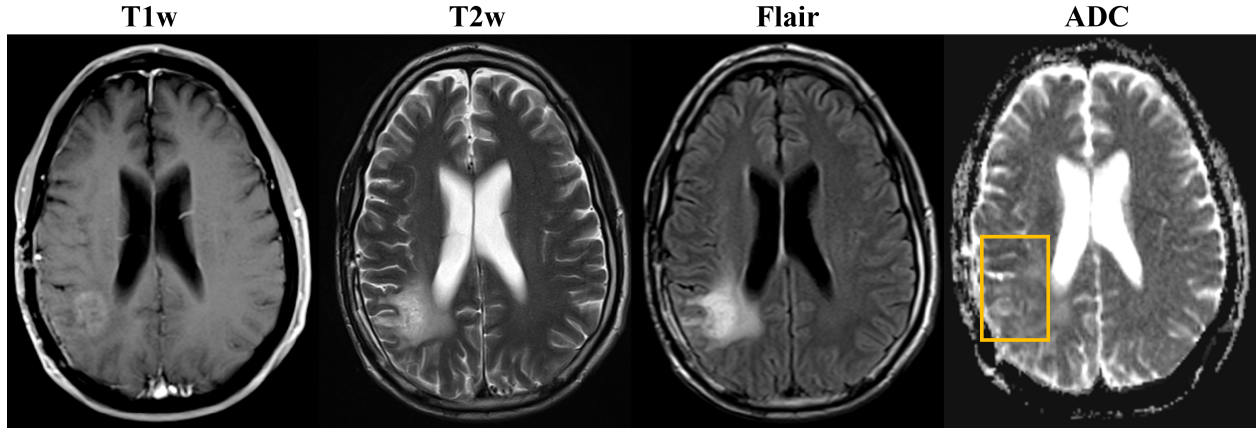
Types of MRI Sequences.
